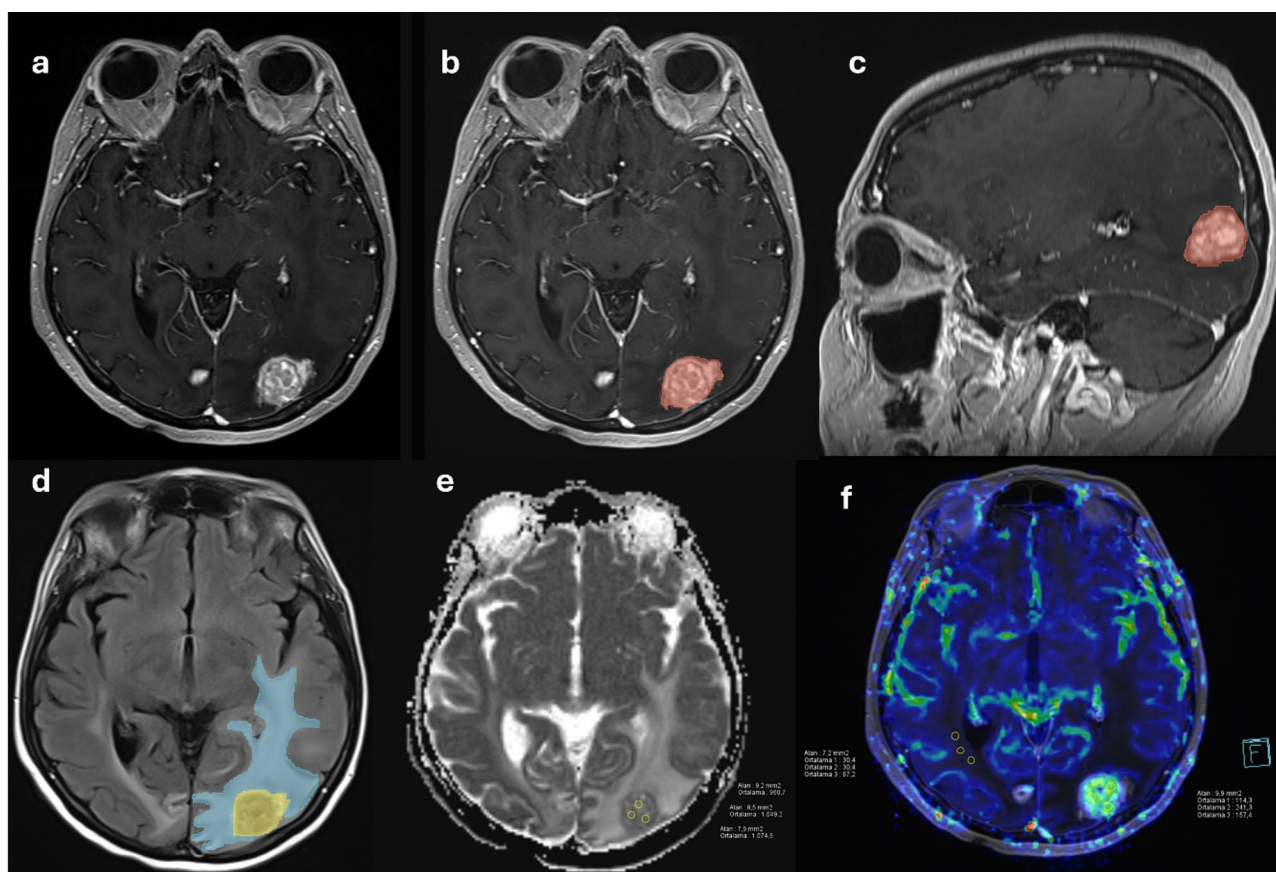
(a) Pre-SRS imaging in a case with brain metastases from breast cancer shows the contrast-enhanced T1-weighted 3D image of the tumor. (b, c) Semi-automatic segmentation of the tumor in axial and sagittal views. (d) Semi-automatic segmentation of perilesional edema on axial FLAIR images. (e, f) ADC and perfusion images demonstrating ADC and rCBV measurements
